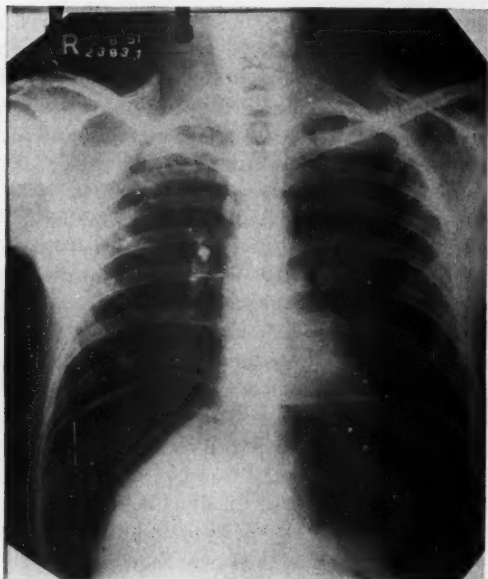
Residual caseous disease, right upper lobe. Preoperative roentgenogram
